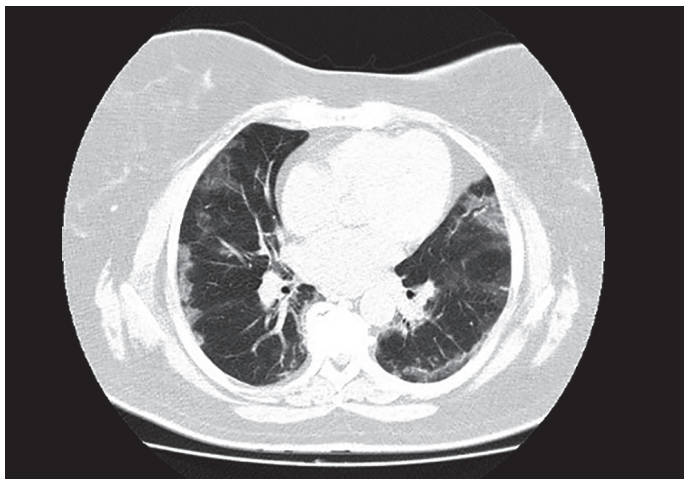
Chest-CT at admission.
